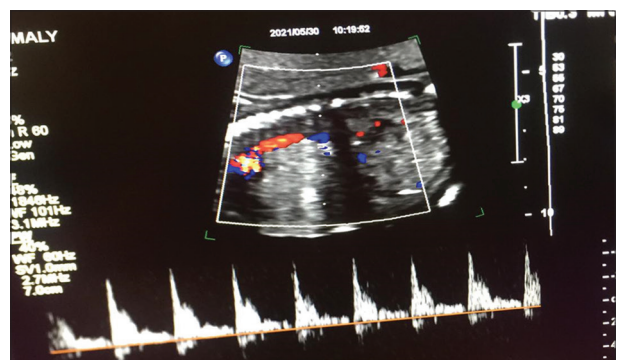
Peak systolic velocity of feeding vessel in Doppler ultrasound that resembles an aortic wave
